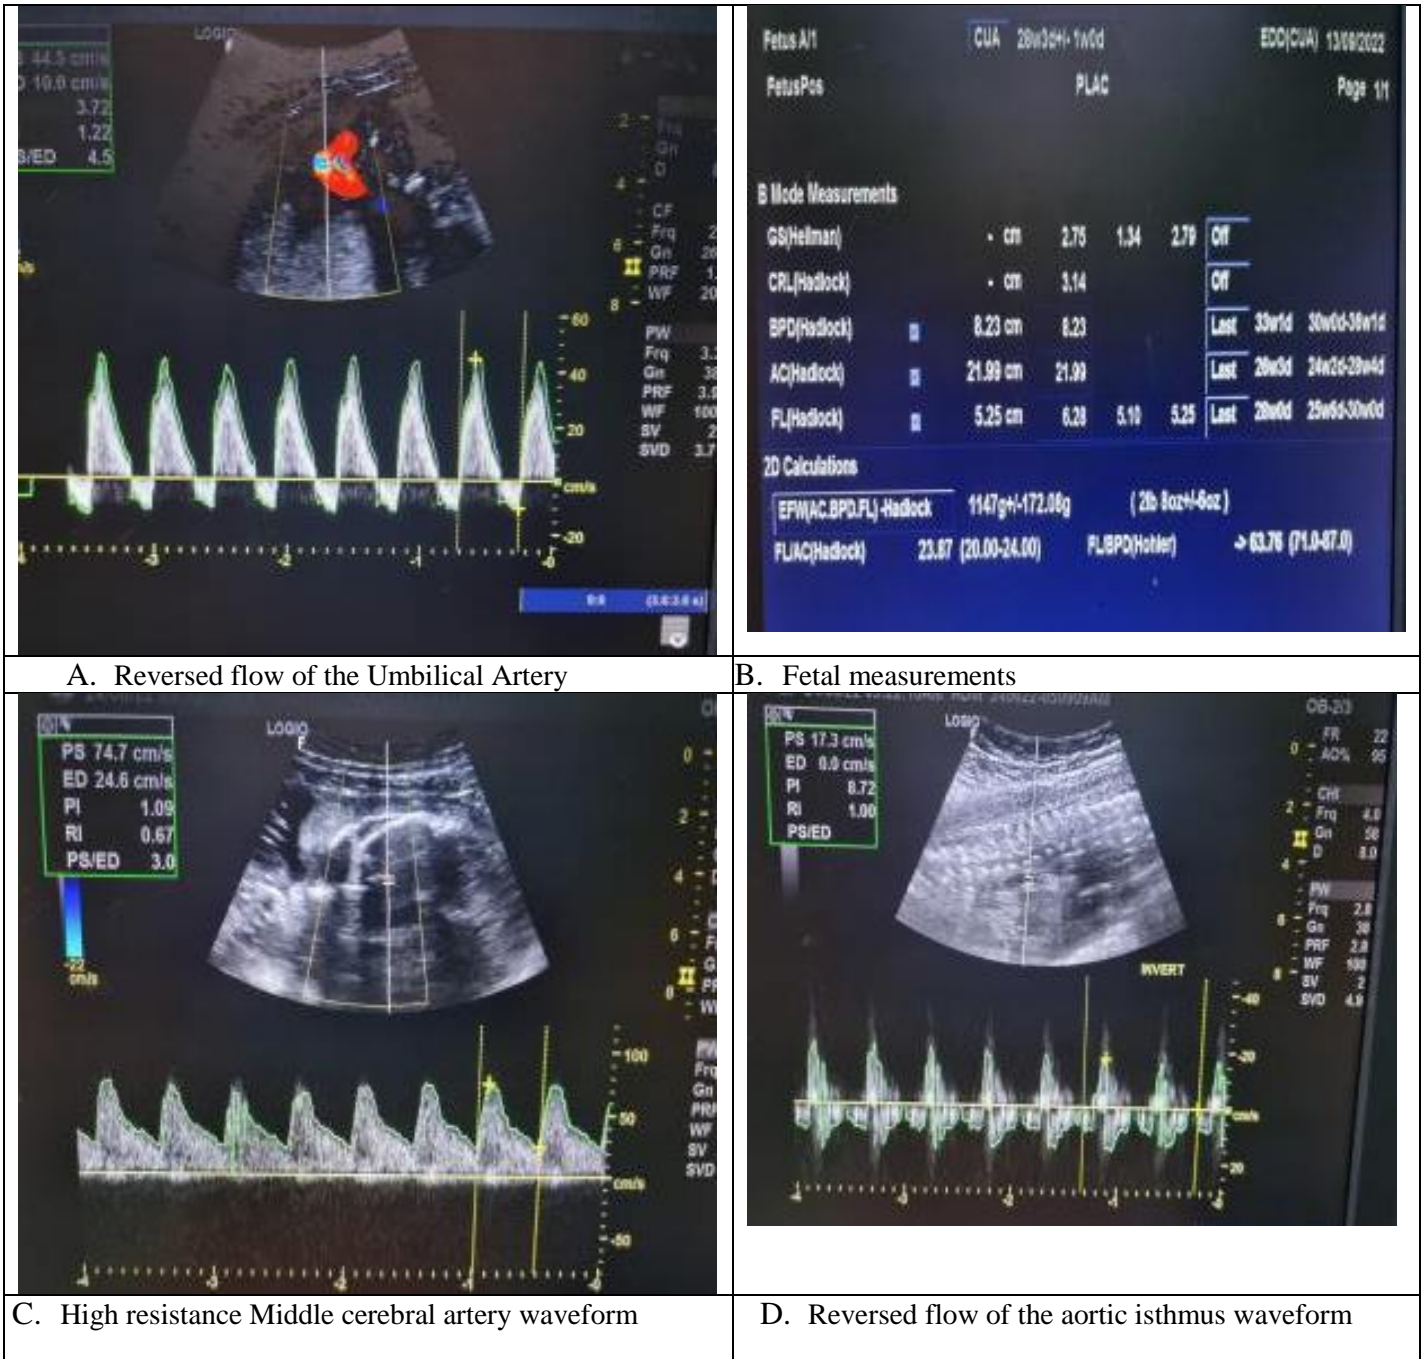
Pregnant female 27 years old, gravida 3, not diabetic or hypertensive, gestational age by LMP was 34 weeks and 2 days, Gestational Age GA by U/S was 28 weeks and 3 days, estimated fetal weight EFW by U/S was 1147 ± 172 grams. Middle cerebral artery resistive index MCA RI = 0.67, Umbilical artery resistive index UMB A RI showed reversed flow and aortic isthmus also showed reversed flow, Amniotic fluid index AFI = 11 (normal), she was delivered by CS. The outcome was NICU admission. A case of asymmetrical IUGR with Doppler examination showed brain sparing effect with reversed flow of the aortic isthmus waveform.
